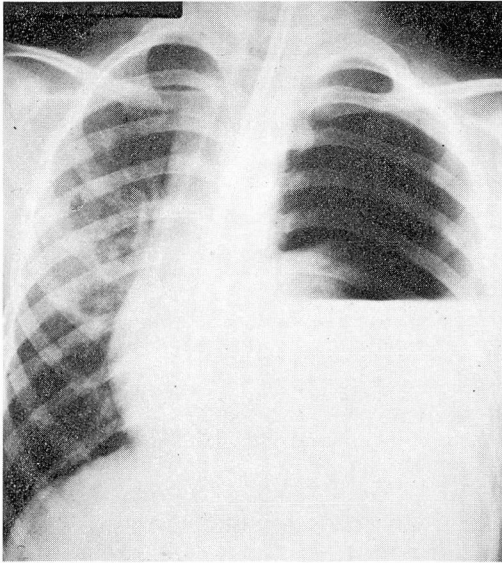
The most striking change on the roentgenogram is evidence of a tension pneumothorax on the left, with a large air-fluid level. The collapsed lung is shown in the hilar region above the fluid level.
